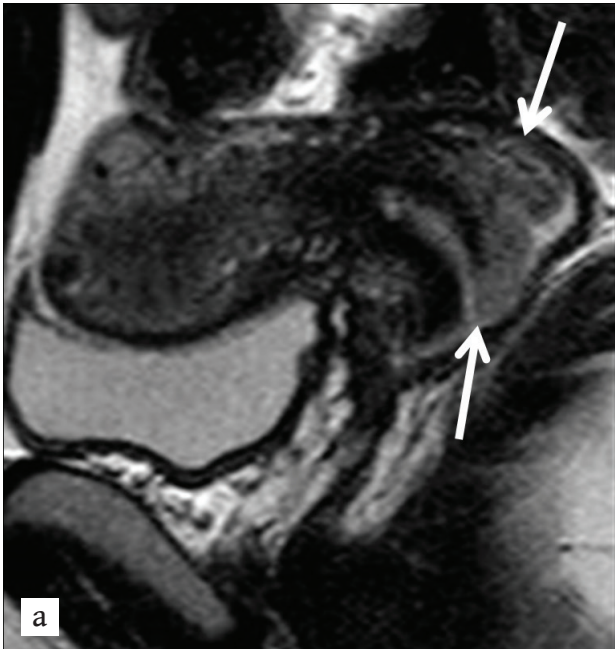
Sagittal T2W images (TR/TE: 3500/90) of a 29-year-old patient with IB1 cervical cancer, before (a) and six months after (b) ART. Pre-operative MRI shows an exophytic cervical tumour extending to the posterior vaginal fornix (arrows in a). On follow-up MRI (b) a low signal intensity line traversing the end-to-end anastomosis (white arrow) is due to the permanent cerclage suture. Also note diffuse vaginal wall thickening, a common post ART finding (c) Corresponding sagittal dynamic contrast-enhanced image, early arterial phase (30 sec) shows lack of enhancement in the region of the anastomosis, which practically excludes tumour recurrence (white arrows); also shown is the cerclage suture around the anastomosis
